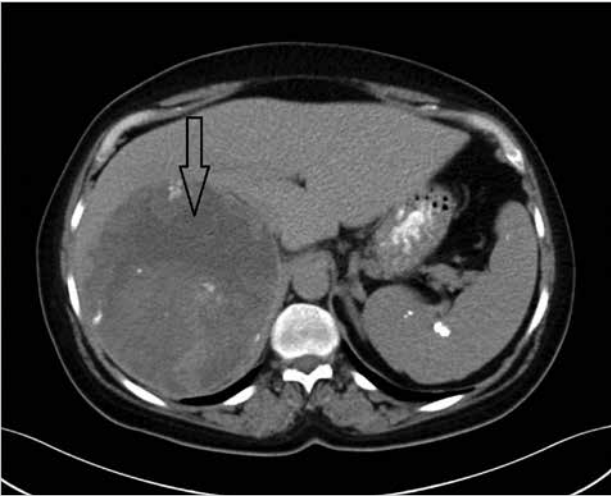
Computed tomographic images of the tumor
